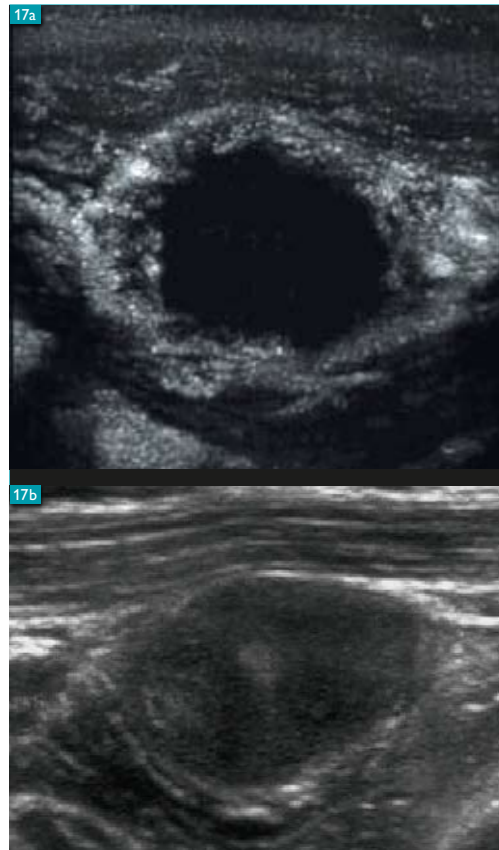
Contrast-enhanced ultrasound shows a characteristic “ring enhancement” due to metastatic invasion of an axial lymph node in a patient with breast cancer. Images by courtesy of B. Porter, USA.
